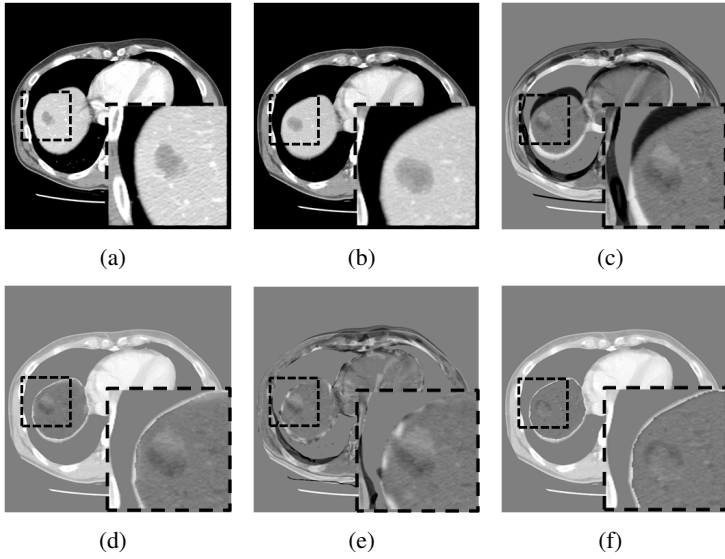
Comparison of \mathbf{NR}_{SPH} , $\mathbf{NR}_{B-spline}$ [1, 2], and $\mathbf{NR}_{Proposed}$ for a slice taken from CT scans with noticeable metastasis changes. The metastasis is enclosed by the dotted rectangle. (a) and (b) are CT slice images taken at times t_0 (source image) and t_1 (target image), respectively. (c) is a subtraction image between the source and target images before registration. (d)-(f) are subtraction images between the target image and the registered-source image with \mathbf{NR}_{SPH} , $\mathbf{NR}_{B-spline}$ [1, 2], and $\mathbf{NR}_{Proposed}$, respectively.
